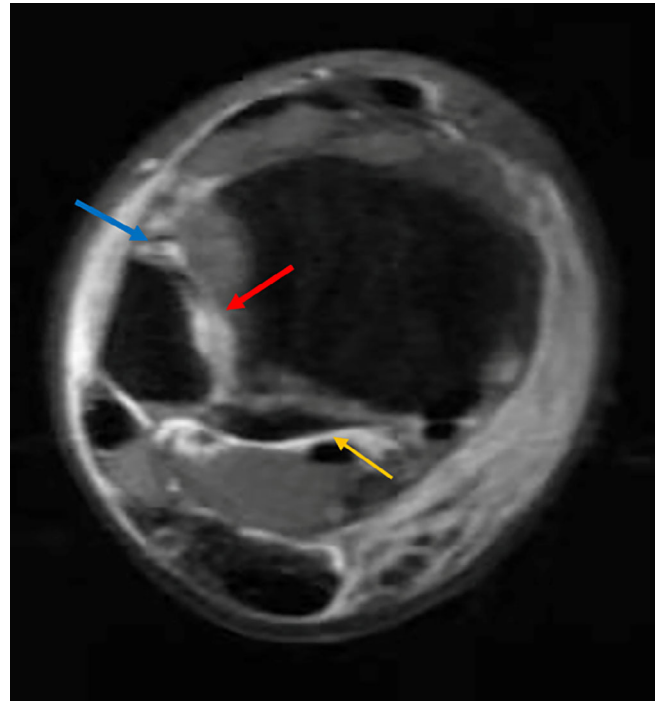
The axial MRI (cross-sectional FS T2WI images) of the ankle joint showing complete rupture of the anterior inferior tibiofibular ligament (AITFL) and interosseous ligament and fracture of the posterior malleolus (red arrow: complete rupture of interosseous ligament; blue arrow: complete rupture of AITFL; yellow arrow: posterior malleolar fracture)
